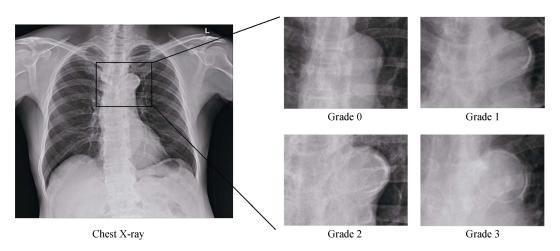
Assessment of aortic arch calcification from chest X-rays.
